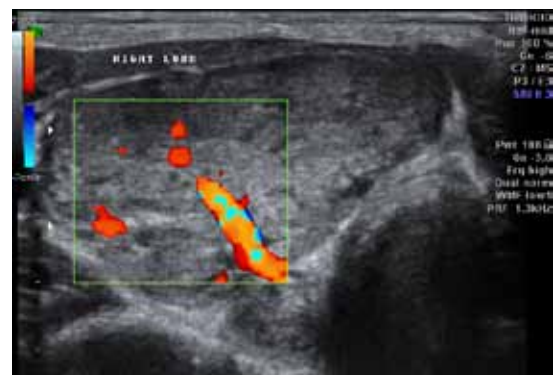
Increased vascularity noticed on Doppler examination.
